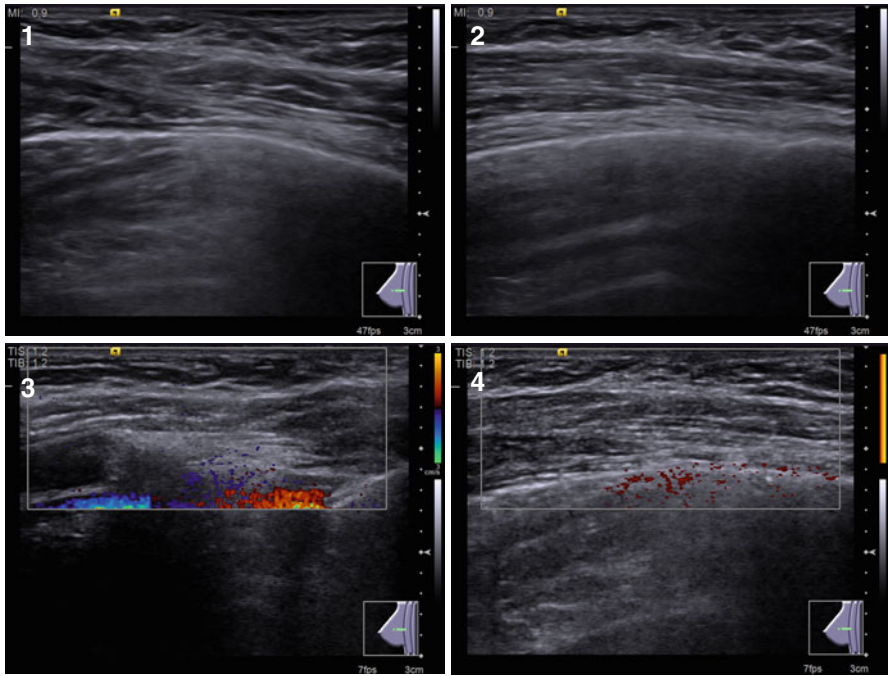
(1–4) Healthy breast, 8-year-old boy. Grayscale US, color Doppler imaging (CDI), and power Doppler imaging (PDI)
